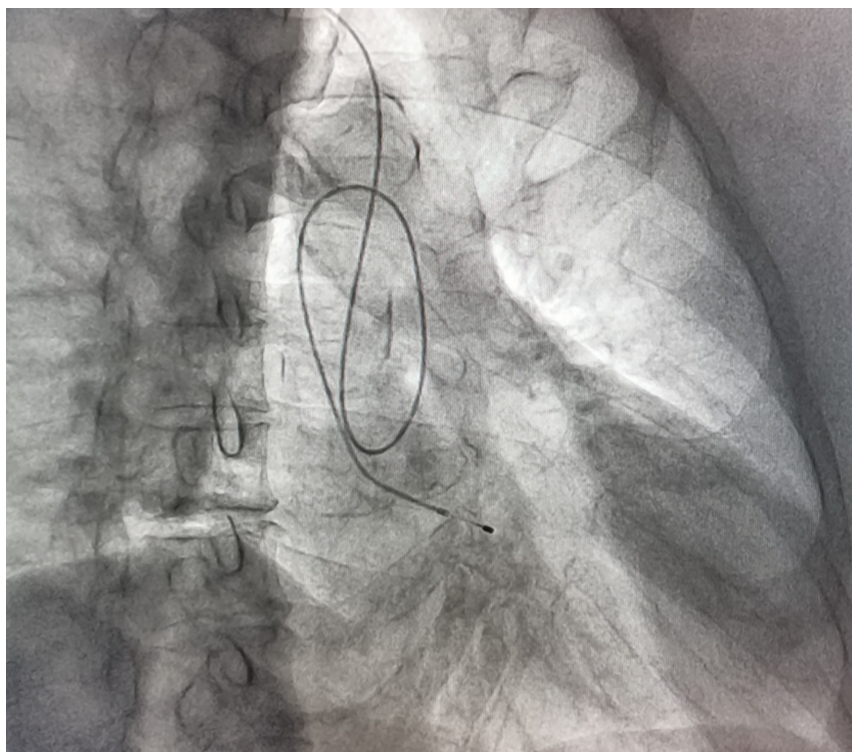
X-ray showed an abnormal lead path.
